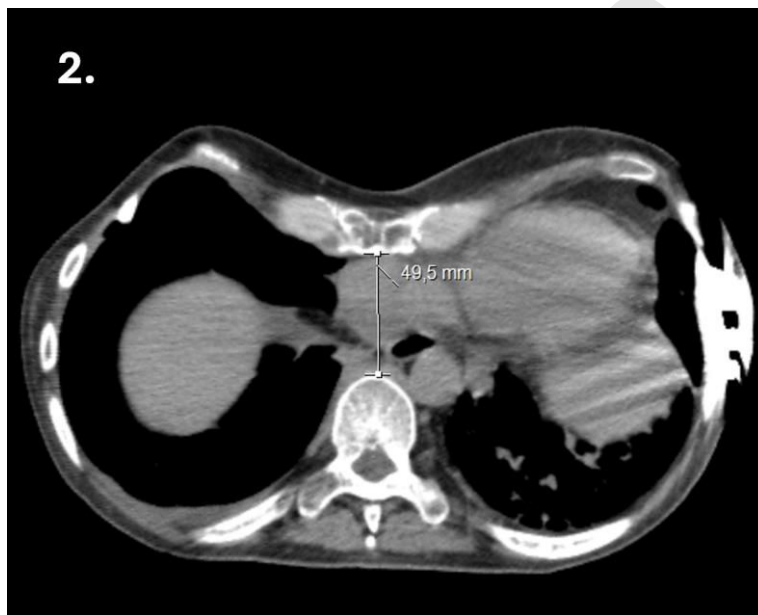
A computed tomography scan axial slice after the Nuss procedure showing the post-operative result with an antero-posterior diameter of 49.5 mm.
